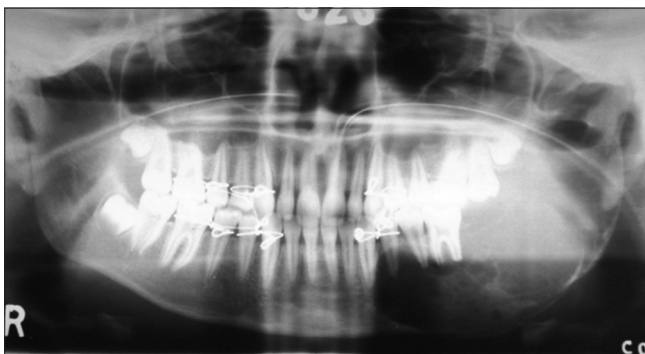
Three months post operative orthopantomogram showing successful bone regeneration
